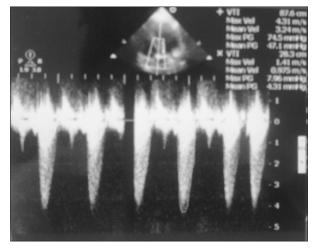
Transthoracic echocardiography with pulse wave Doppler showing high pressure gradient across aortic valve
